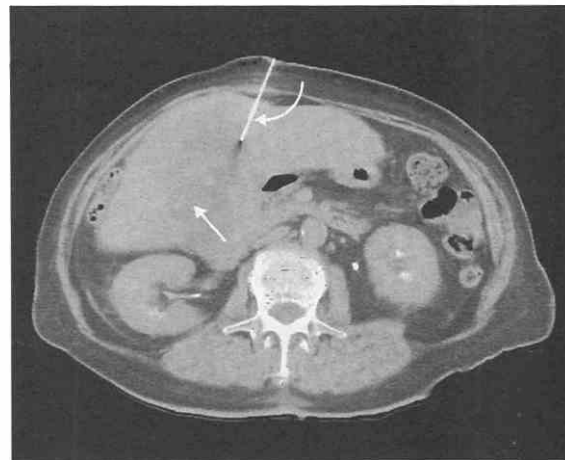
CT scan shows biopsy needle (curved arrow) in mass in central liver, representing gallbladder carcinoma from intrahepatic gallbladder. Note the faceted stone (arrow) surrounded by fluid in the central liver.
